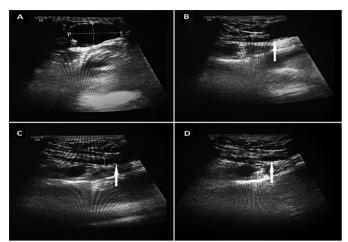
Ultrasonography image of the right inguinal region showing an anechoic cysticlesion of approximately 31×17mm in size (A). The pathognomic feature of the cyst of the canal of Nuck, a comma-shaped tail (arrow) directed to the inguinal canalis shown (B, C, D).
